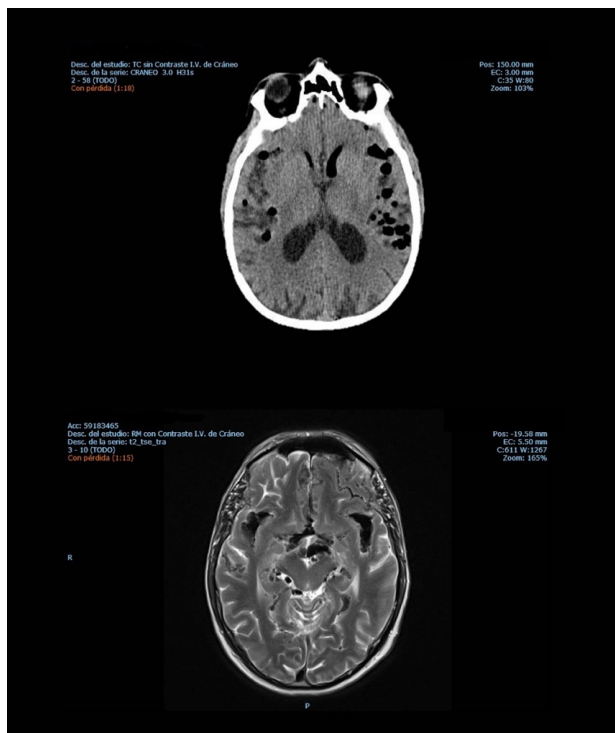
Displays non-contrast computed tomography and magnetic resonance imaging, providing visual evidence of the presence of air bubbles within the brain.
